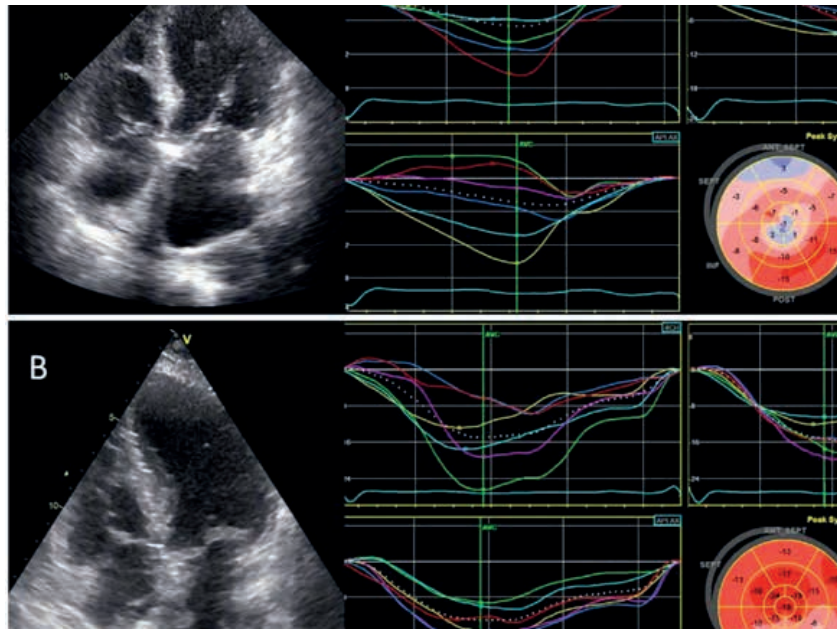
Improvement in left ventricular systolic function after transcatheter aortic valve implantation in an 83 year old female with severe aortic stenosis. Panel A shows the baseline left ventricular systolic function measured with conventional transthoracic echocardiography (LVEF 31%) and speckle tracking echocardiography (global longitudinal strain -5.9%). At 6 months follow-up, LVEF normalized and global longitudinal strain improved to -14.6% (panel B).
